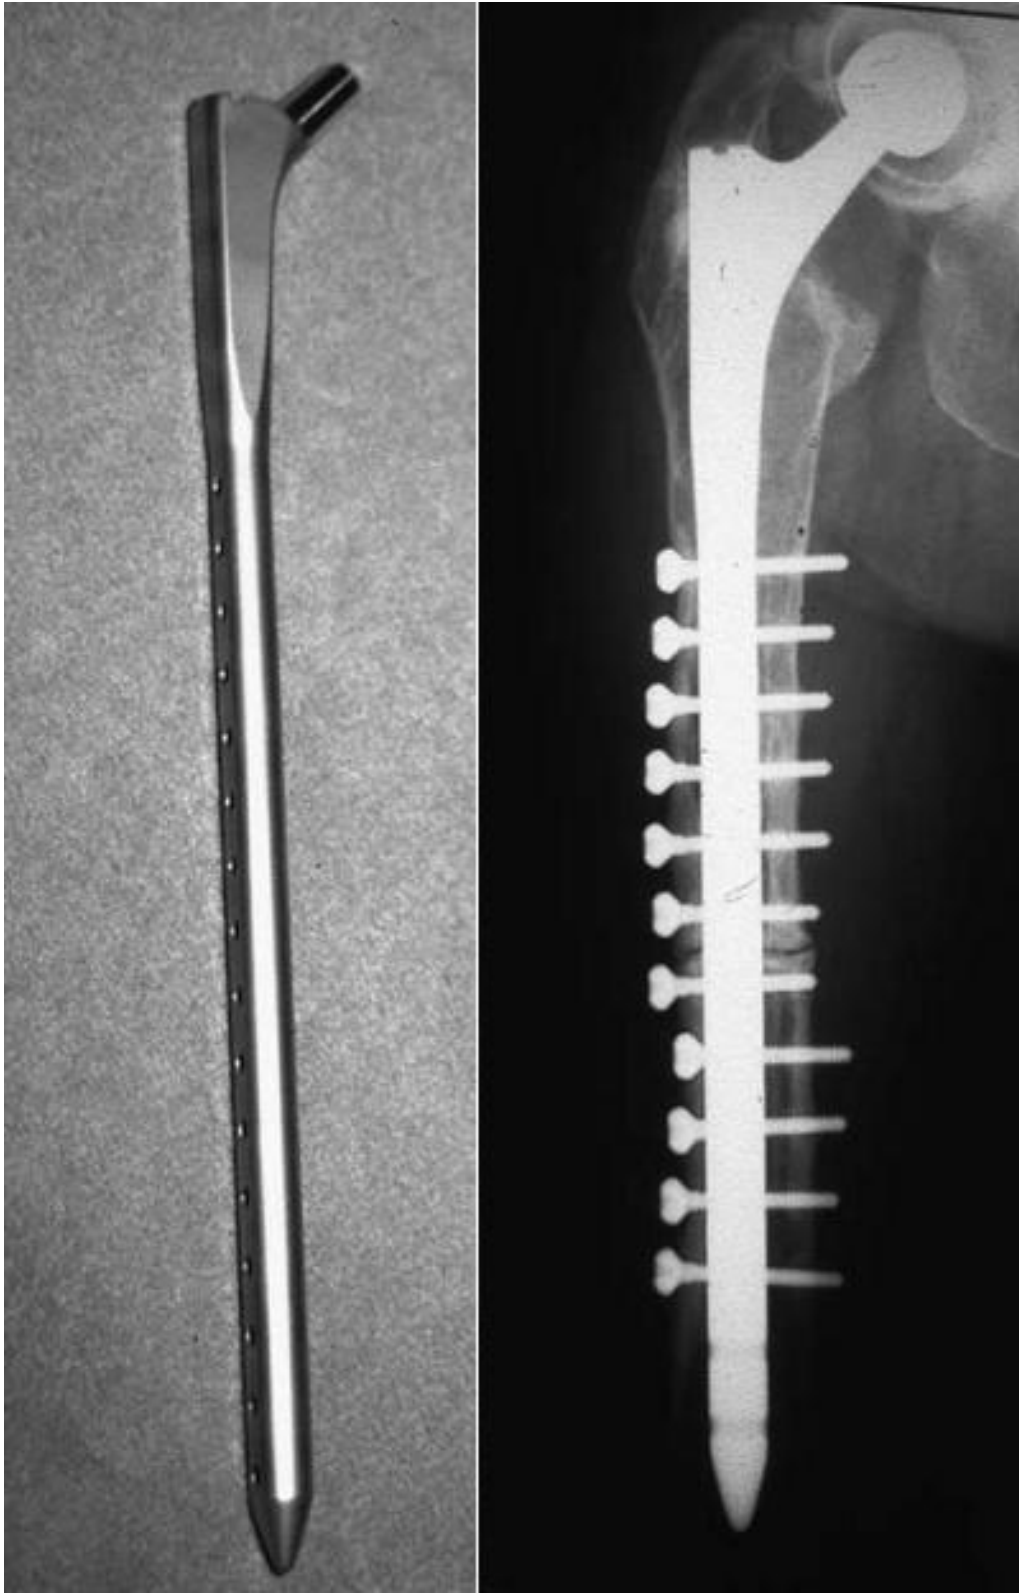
The Kent Hip System is a long-stemmed and offers options for locking along the stem allowing for fixation both above and below a fracture as seen in radiograph
